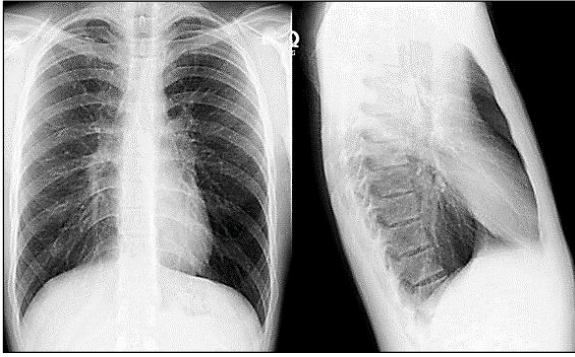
Chest radiograph of chronic obstructive pulmonary disease
